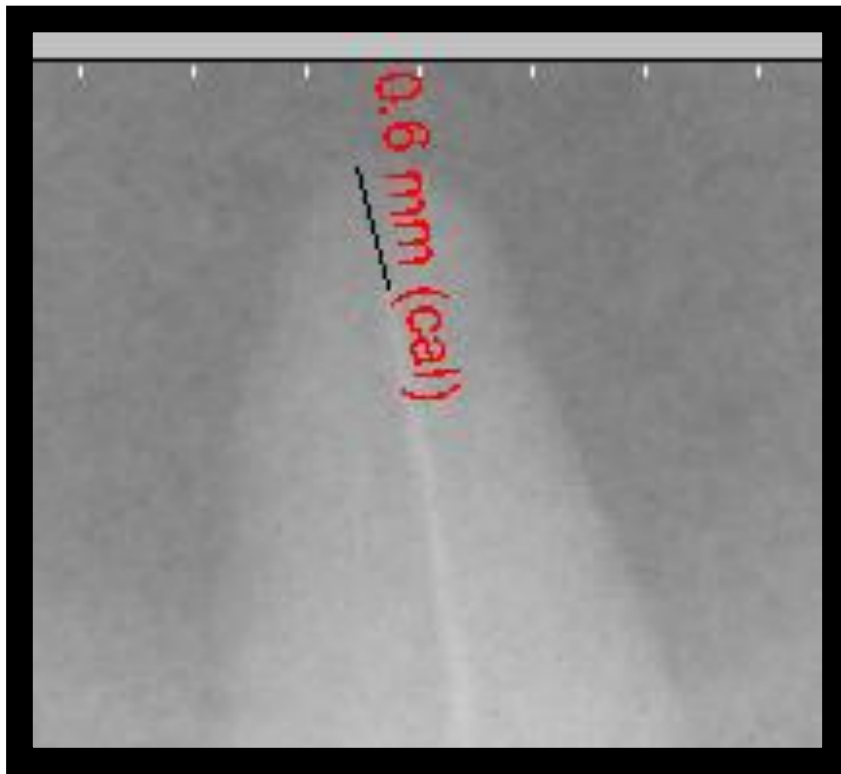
Measurement from file tip to radiographic apex.
